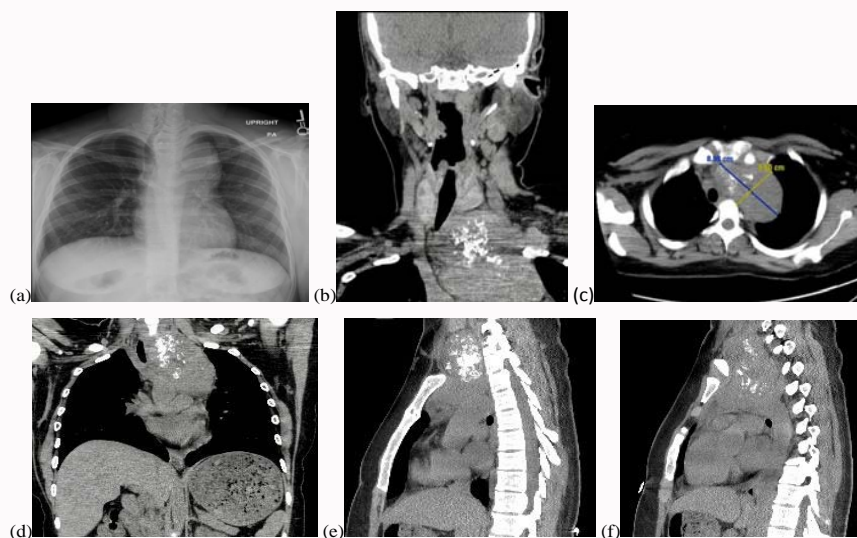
Pre-operative imaging. Initial chest radiograph demonstrates marked upper mediastinal widening with rightward tracheal deviation and narrowing (a). Initial non-contrast CT examination shows a large solid isoattenuating mass anterior to the ascending aorta (b-f). There is extrathoracic extension into the neck with this component demonstrating extensive calcification and causing superior displacement of the left lobe of the thyroid (b, e). Note the preserved fat plane between this mass and the left thyroid, confirming the mass is not of thyroid origin (b, e). The mass directly abuts and displaces the aortic arch and great vessels posteriorly, with the left subclavian artery visualized adjacent to the thoracic spine (c, f). The left common carotid artery is inseparable from the mass. The left brachiocephalic, common carotid, and subclavian veins are also inseparable from the mass.
